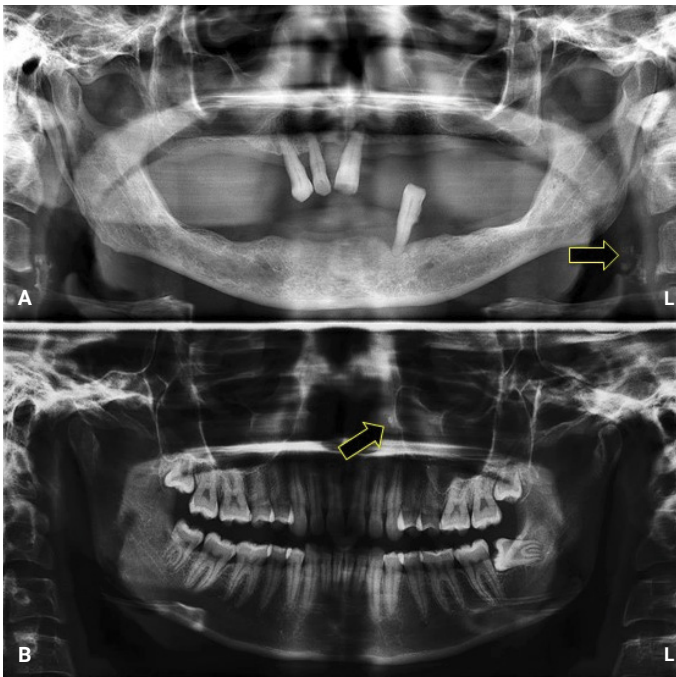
(A) The arrow on the panoramic radiograph showing a well-defined radiopacity with a “cauliflower appearance” near the mandibular angle suggestive of calcified lymph node. (B) The arrow on the panoramic radiograph showing a well-defined radiopacity close to the nasal fossa on left side suggestive of rhinolith (The contrast of the radiograph is altered for better visualisation of the calcification).
